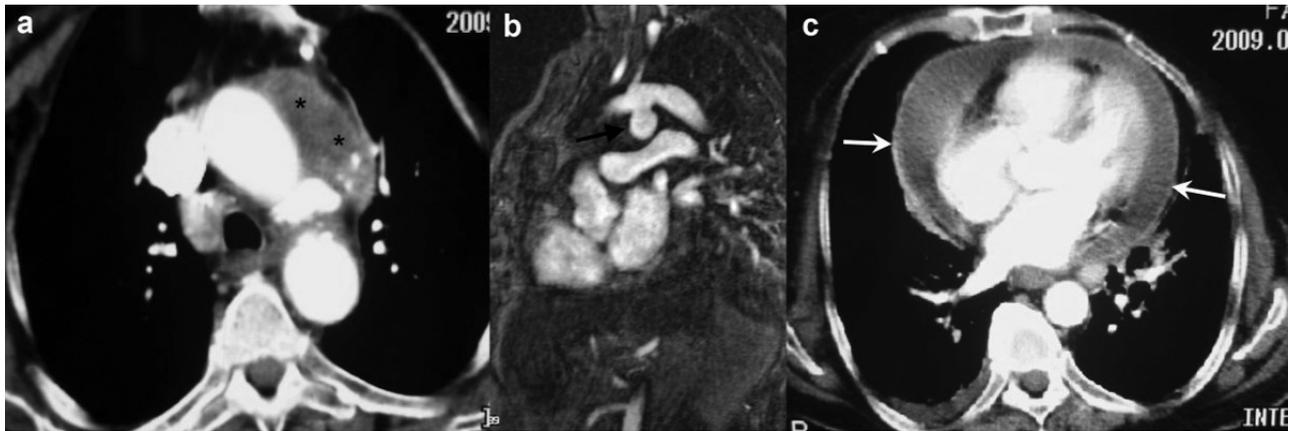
a: Axial contrast CT image *intramural hematoma (IMH)* (black star) b: Sagittal T2 weight image *penetrating aortic ulcer (PAU)* (arrow) c: Axial contrast CT image pericardial effusion
